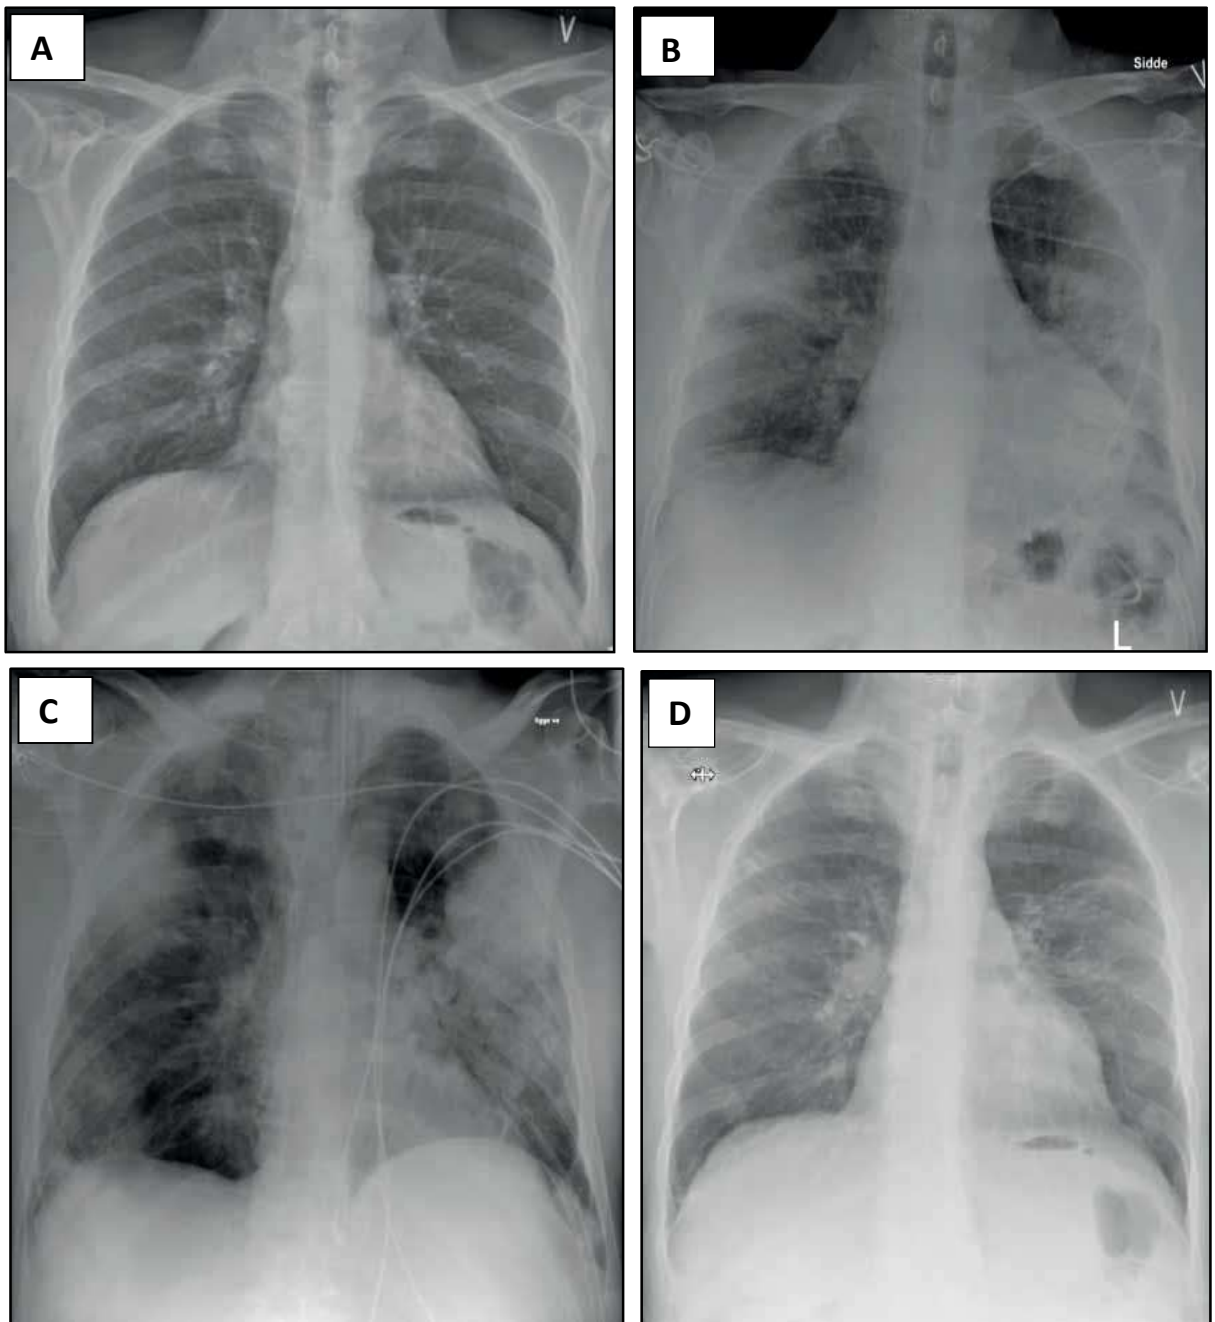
Chest x-rays of COVID-19 patient A) 11 months prior to the admission to hospital. B) On the day of admission. C) 4 days post admission. D) Approximately 2 months post admission. Reticular-pattern persists but the b/l opacities have diminished.⁸⁰
